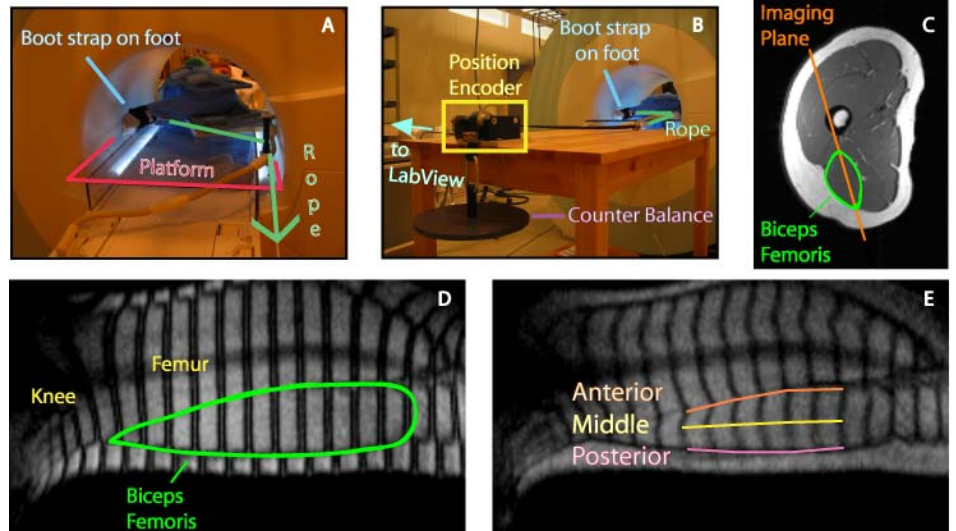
Volunteer lying in MRI scanner at full flexion (A,B). Axial view of thigh and imaging plane (C). Undeformed tag image (D). Deformed tag image with anatomical regions labeled (E).
